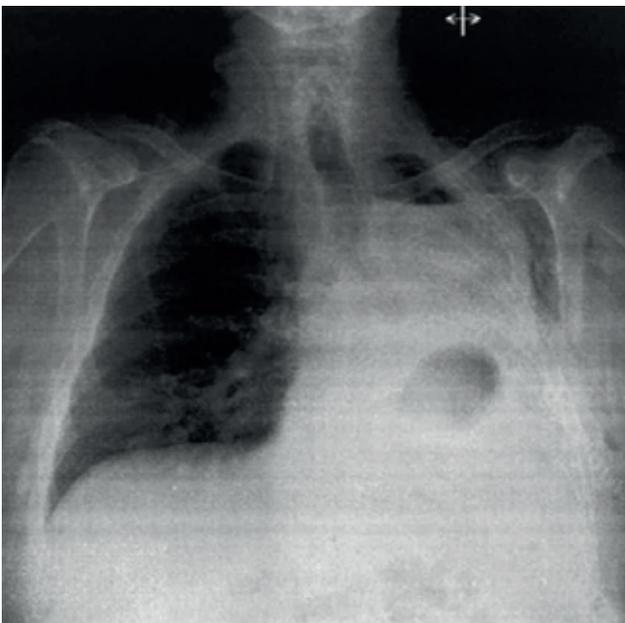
Portable chest X-ray on discharge.
